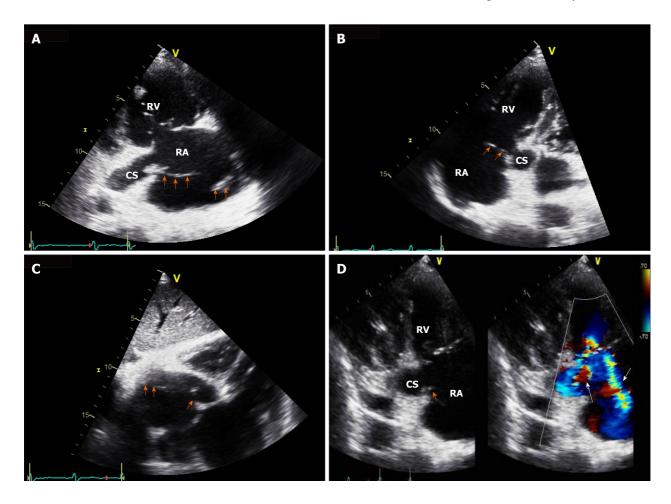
Echocardiographic imaging. A: Right ventricular inflow view showing a mobile band-like vegetation, approximately 8 cm in size, attached to the coronary sinus ostium and the posterolateral wall of the right atrium; B: Modified apical four-chamber view showing a vegetation attached to the ostium of the coronary sinus; C: Subcostal view showing a vegetation; D: Right ventricular inflow view showing eccentric tricuspid regurgitant jet flow directed towards the coronary sinus and concentric tricuspid regurgitant jet flow directed towards the posterolateral wall of the right atrium, observed through color Doppler imaging, and an attached vegetation at the site, observed via two-dimensional imaging. Orange arrow indicates vegetation; White arrow indicates directed tricuspid regurgitant jet flow. RA: Right atrium; RV: Right ventricle; CS: Coronary sinus.
